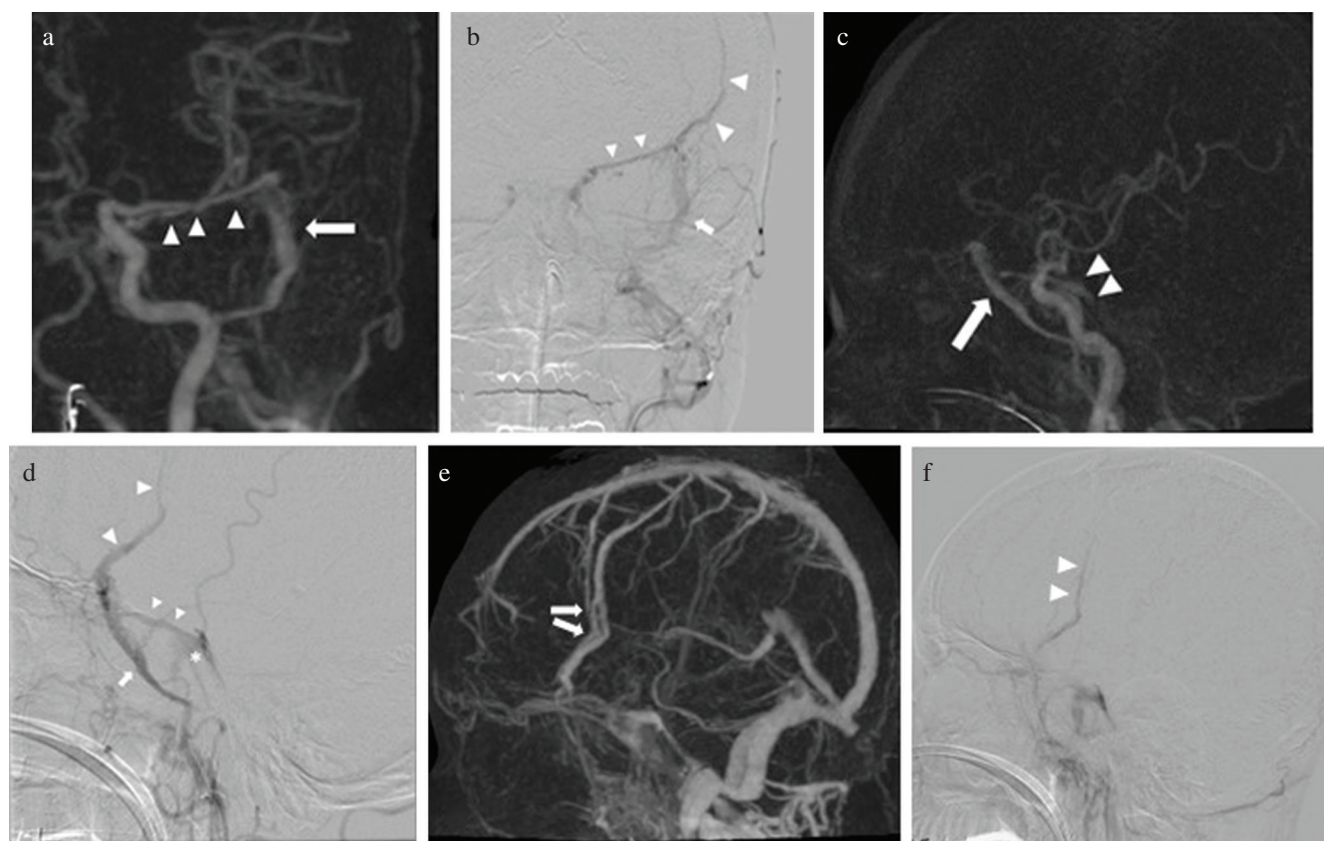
(a) Four-dimensional anteroposterior computed tomography angiography (4D-CTA) revealed abnormal blood flow in the middle meningeal artery (MMA) (arrow) with a continuous stream toward the median (arrowheads). (c) Lateral CT angiography also revealed a dilated MMA (arrow) and cavernous sinus detected in the late arterial phase (arrowheads). Left (b) anteroposterior and (d) lateral external angiography showed an AVF fed by the anterior branch of the MMA (arrow). The adjacent middle meningeal sinus was caught by arterial blood, shaping the fistulous point into a dilated high-flow tangle. Venous drainage flowed into the cavernous sinus (asterisk) through the sphenoparietal sinus (small arrowheads) and through the anterior temporal diploic vein (large arrowheads) in a retrograde upward manner. (e) 4D-CTA detected late-venous phase anterior temporal diploic vein (ATDV) filling rather than normal venous return (arrow). (f) Left lateral external angiography showed to-and-fro stream of the ATDV in the late venous phase (arrowhead), indicating venous congestion and resulting in venous infarction in the left cerebral hemisphere. AVF: arteriovenous fistula.
